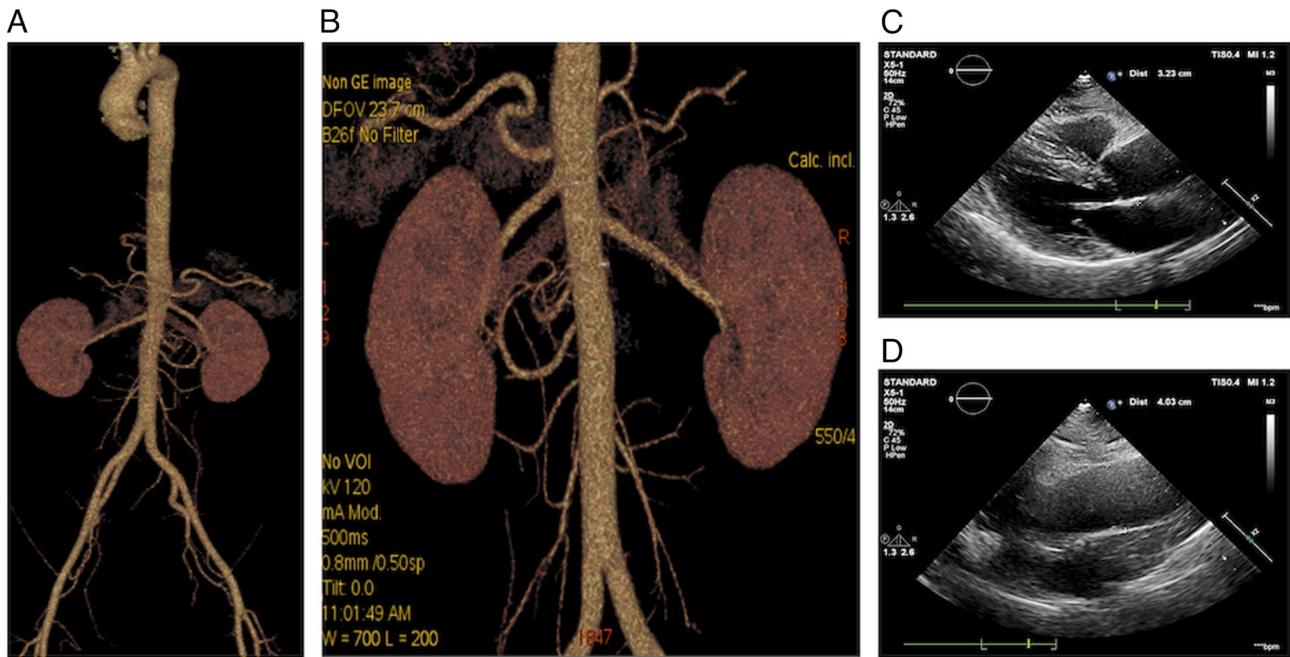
Imaging examination results of the proband. (A) Aortic artery computed tomography revealed normal findings. (B) Renal artery computed tomography also revealed a normal result. (C) Transthoracic echocardiography indicated thickening of the left ventricular posterior wall and interventricular septum. (D) Transthoracic echocardiography revealed the widening of the ascending aorta.
